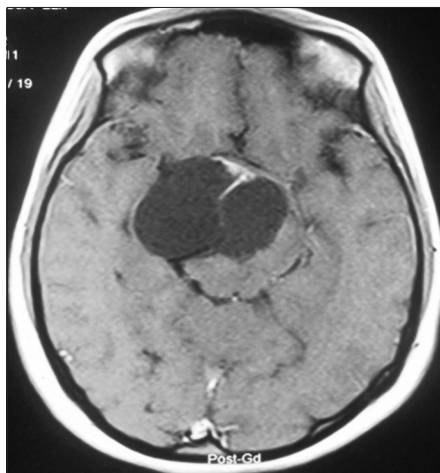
Preoperative contrast magnetic resonance imaging scan showing craniopharyngioma
